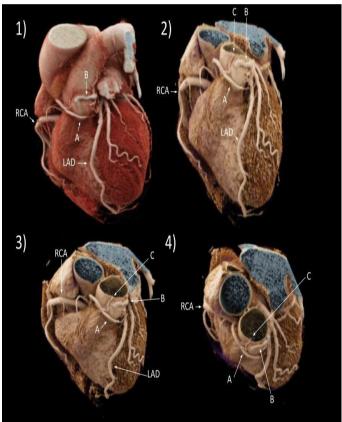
Cardiac CT 3D Volumetric reconstruction. 1, 2, 3) Frontal view; 4) Superior view.
